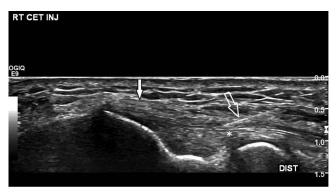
Sonographically guided CET prolotherapy injection with CET (arrow) and radial collateral ligament (asterisk) seen in anatomic long axis view with the needle (open arrow) guided in an in-plane, distal-to-proximal technique. The radius is distal, to the right, and the humerus is proximal, to the left.
